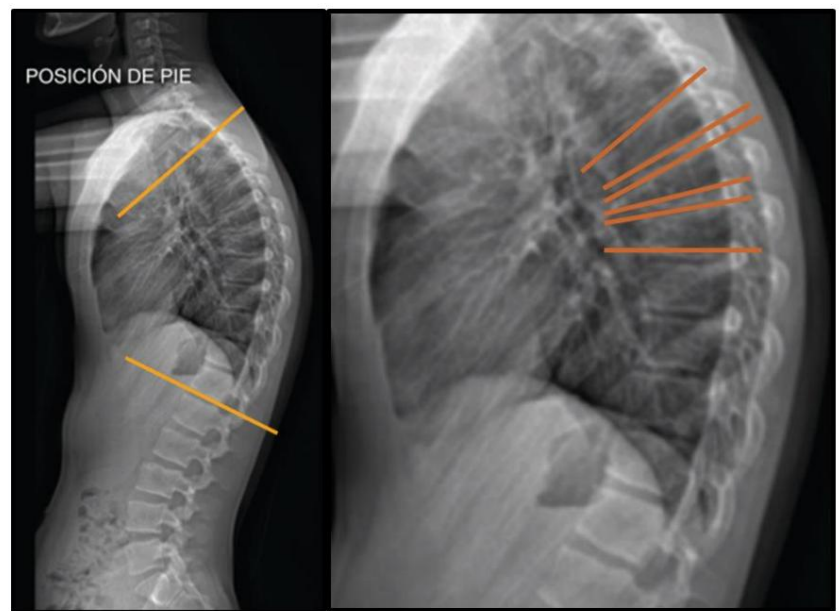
30° X-ray in lateral projection showing a 55° hyperkyphosis with apex in T5 and anterior wedging of three vertebrae.
